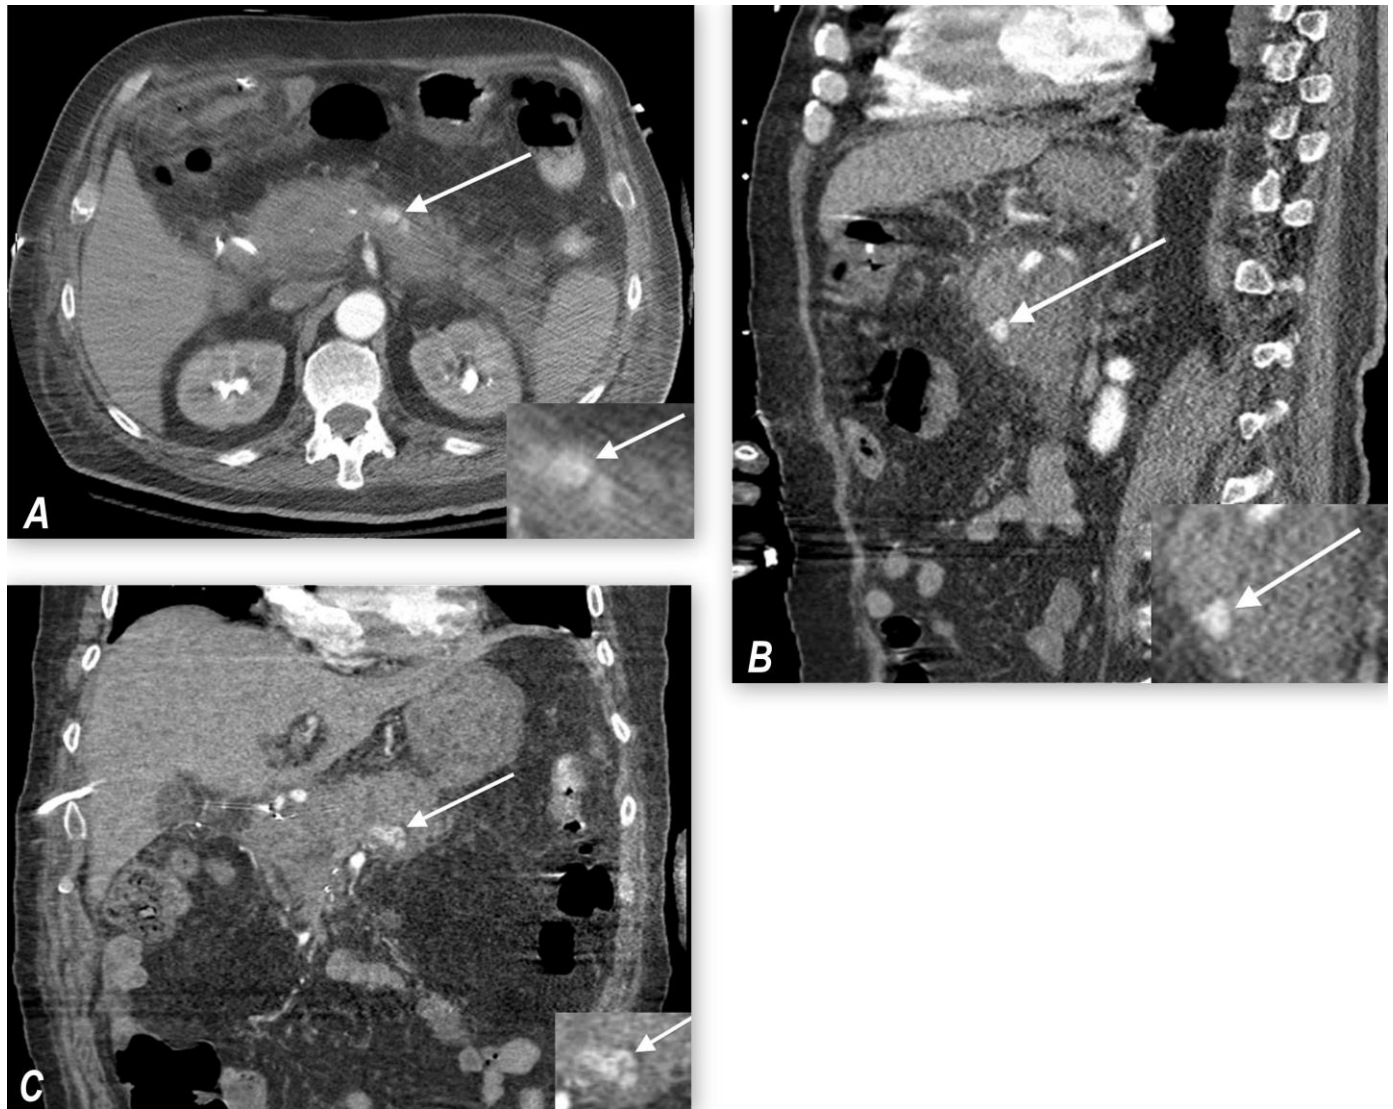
73-year-old male with post-pancreaticoduodenectomy hemorrhage. (a) axial, (b) sagittal and (c) coronal CTA images of the abdomen with magnified coned-down views in the right lower corner show the 18x9x8 mm pseudoaneurysm (arrow) with possible contrast extravasation in the pancreatic bed. [Protocol: 374 mA, 140 KV, 5 mm slice thickness, 100 cc Omnipaque (Iohexol) 350, GE Healthcare, Waukesha, WI]
